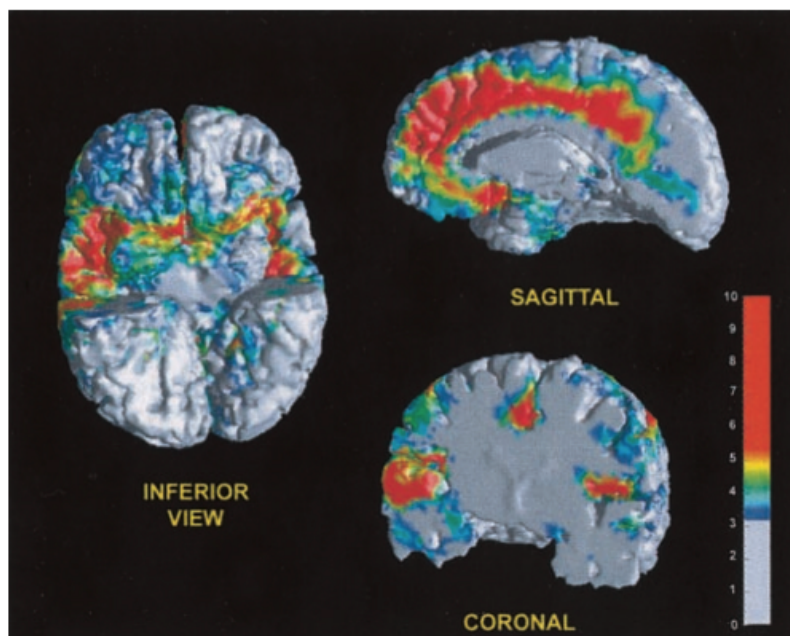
Significant tissue loss in gray matter volume in the insula), orbital frontal cortex, and cingulate cortex, from longitudinal studies through MRI. Adapted from Resnick, Pham et al. (2003)
